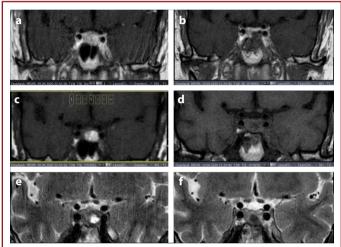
Preoperative (left column); (post-contrast coronal T1 weighted (a); pre-contrast coronal T1 weighted (c); coronal T2 weighted images (e) and postoperative (right column; post-contrast coronal T1 weighted (b), pre-contrast coronal T1 weighted (d), coronal T2 weighted images (f) pituitary MRI of the patient revealed pituitary apoplexy (pituitary adenoma with bleeding). Postoperative pituitary MRI images showed tumor and blood evacuation and decompression of surrounding neurovascular structures.
